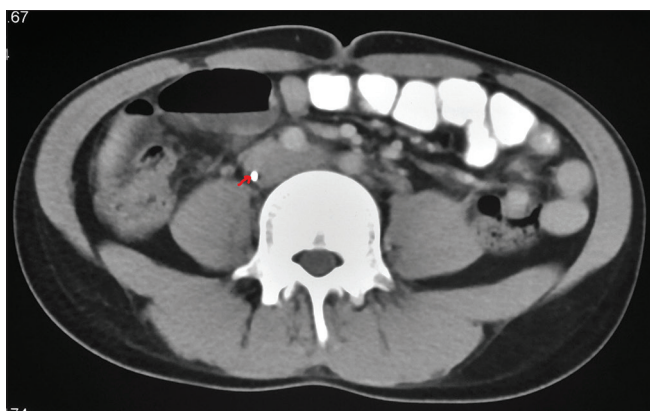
Contrast-enhanced computed tomography (thorax and abdomen) showing linear hyperdense foreign body (red arrow) in inferior vena cava
